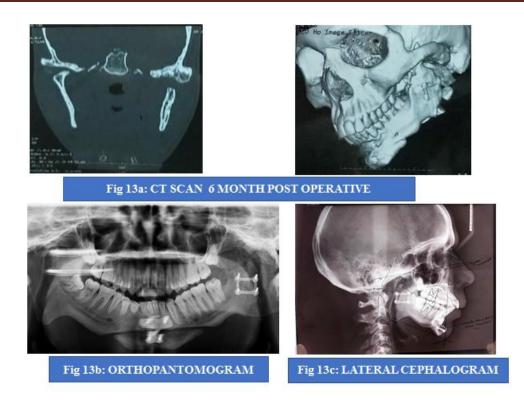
6th MONTH POST OPERATIVE RADIOGRAPH
